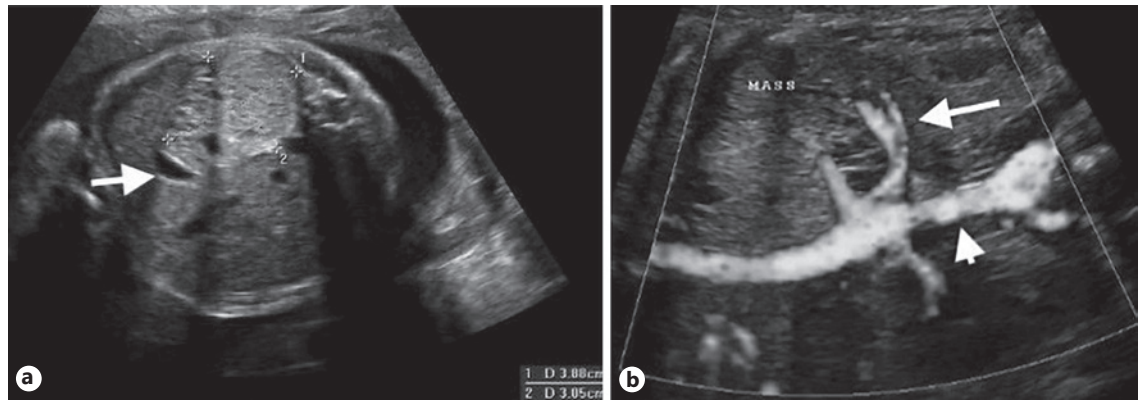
Infradiaphragmatic sequestration. a Transverse gray scale image of a 3.9 cm echogenic mass (calipers) in the left upper quadrant displacing the stomach anteriorly (arrow). b Sagittal power gray-scale Doppler image of the left upper quadrant mass (labeled mass) with a feeding vessel (arrow) arising from the aorta (arrowhead).
